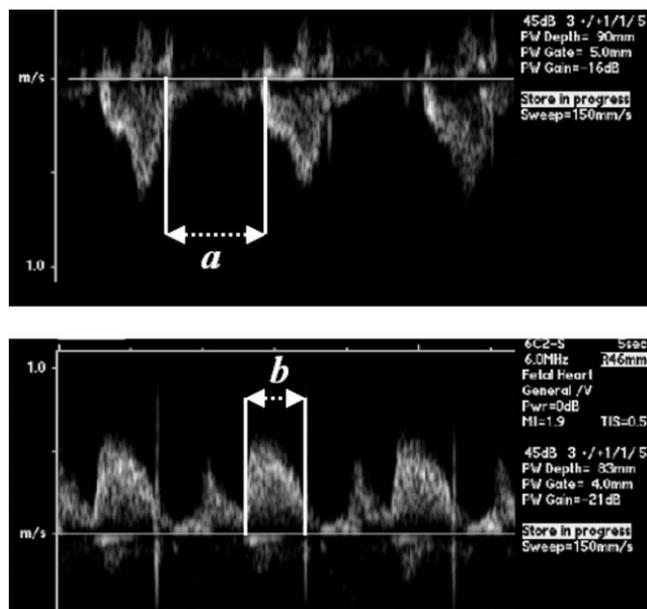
Right ventricular Tei index measurement using pulsed-wave Doppler-derived blood flow velocity waveforms obtained from the pulmonary and tricuspid valves in series. *a*, time interval from closure to opening of the tricuspid valve; *b*, time interval from opening to closure of the pulmonary valve (ejection time); Tei index = $(a - b)/b$.
